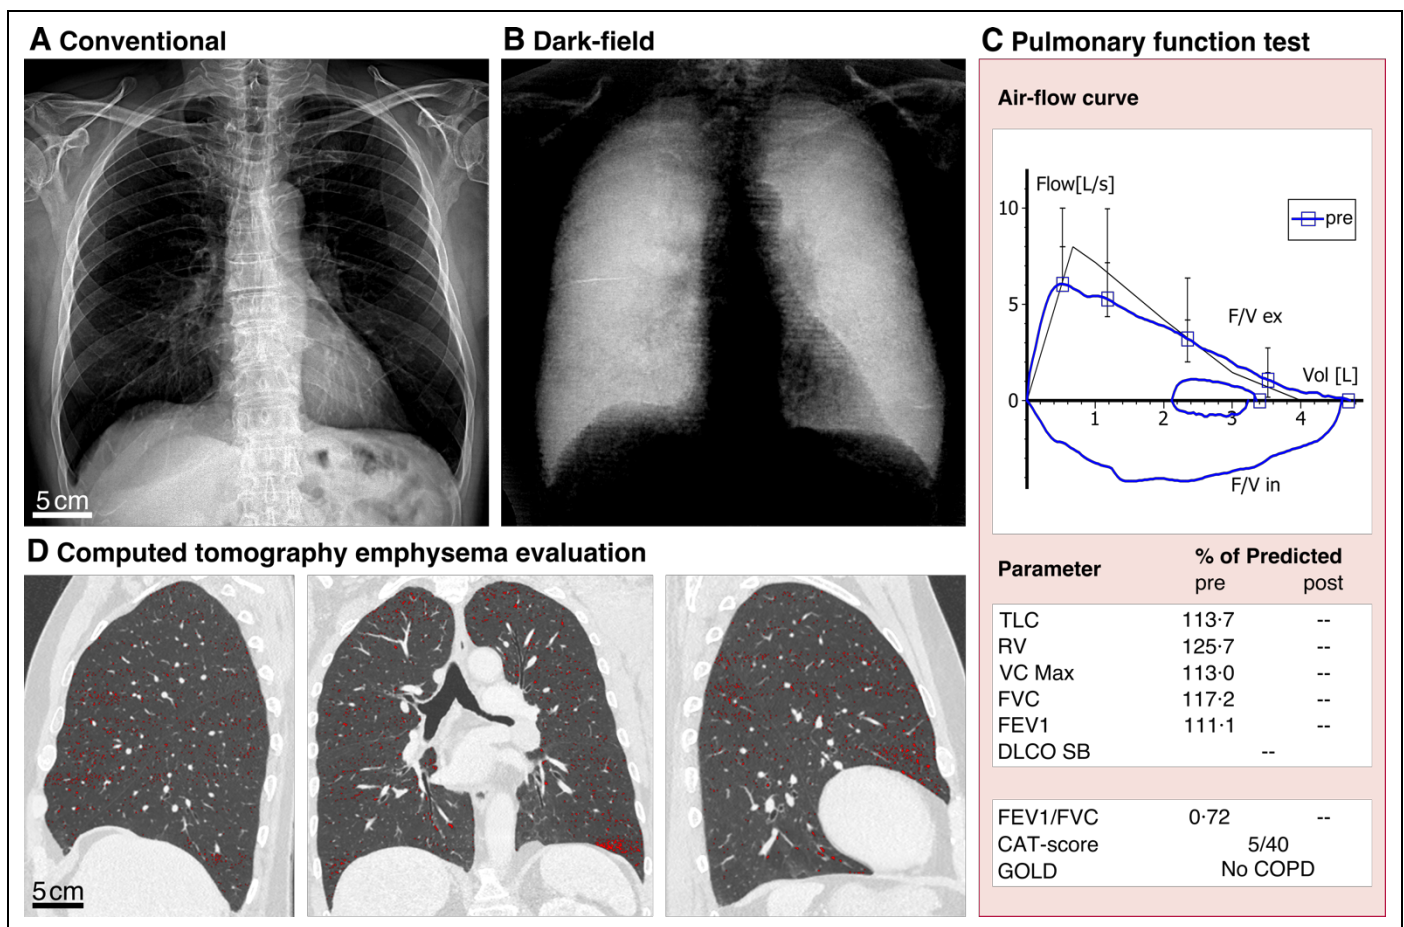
Clinical study results of a patient without COPD. Conventional attenuation (A) and dark-field (B) images of a patient (male, 71 years, BMI 29.2, non-smoker) without clinical indications of COPD. The dark-field image shows a homogeneous signal distribution over the lung with a slightly decreased mean value of 0.28, which might be an indication for a beginning impairment of the respiratory surface. For the attenuation signal, an average value over the entire lung of 2.74 was measured. With an inconspicuous air-flow curve and normal spirometric parameters (C), a healthy condition of the lung is indicated. CT densitometry yields an emphysema ratio of 3.9%, with detected areas being finely distributed over the entire lung, as depicted in the CT slices (D) where corresponding pixels are marked in red.
